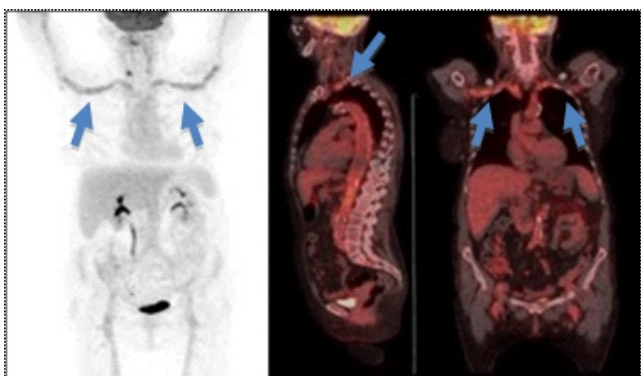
A 72 year old woman with fever, asthenia, headache and weight loss. Whole body CT: pulmonary nodule. ^{18}F -FDG PET/CT: unexpected and occasional findings FDG linear uptake of aortic and large-vessel walls permit the correct diagnosis.
